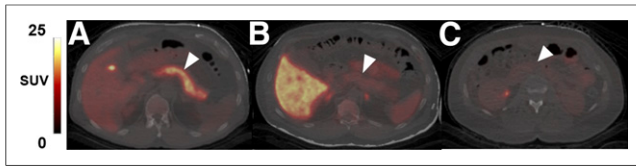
Representative axial slices of PET/CT overlay of pancreas uptake (arrowheads) for each dopaminergic radioligand ^{11}C -(+)-PHNO (A), ^{11}C -FLB457 (B), and ^{11}C -raclopride (C). All SUV images summed from 20 to 30 min.
